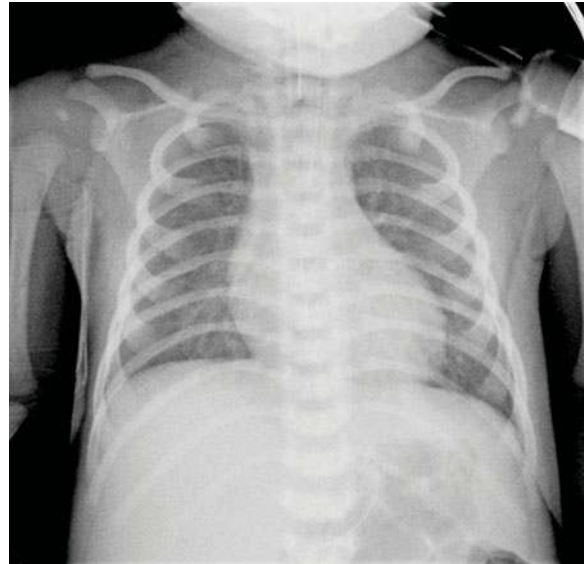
Normal appearance of neonatal chest radiograph
